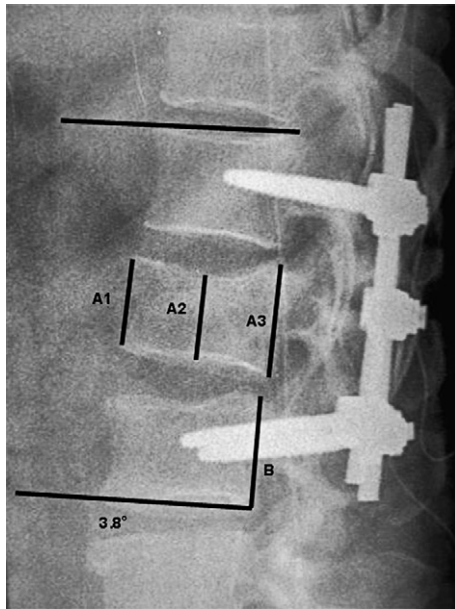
Lateral radiograph showing the various lines used to measure the Cobb angle (in this case, 3.8°) and the different segmental heights of the fractured vertebral body. The corrected anterior vertebral height (A1) is $A1 \times 100/B$.
